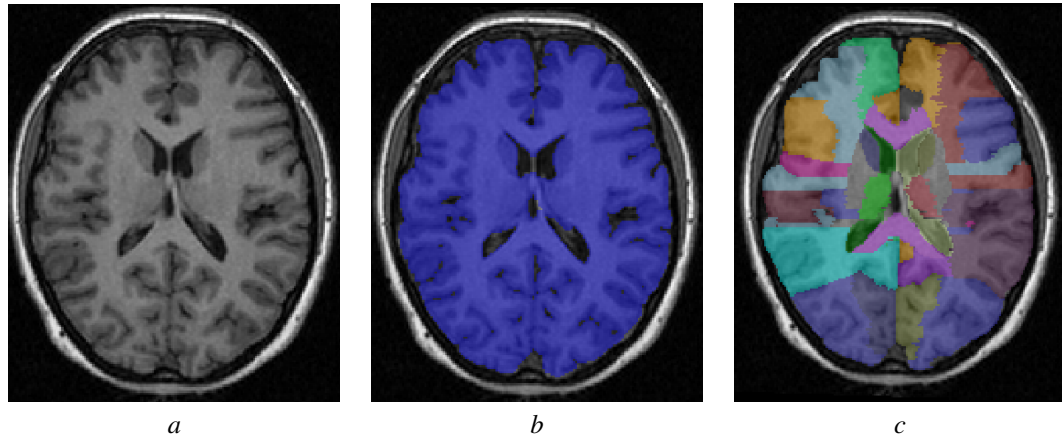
An example of structural parcellation: (a) T1-weighted MRI image of a human brain, (b) brain region-of-interest localization, (c) anatomical parcellation of the brain in its composing sub-structures according to the Hammers protocol (Hammers et al., 2003).
